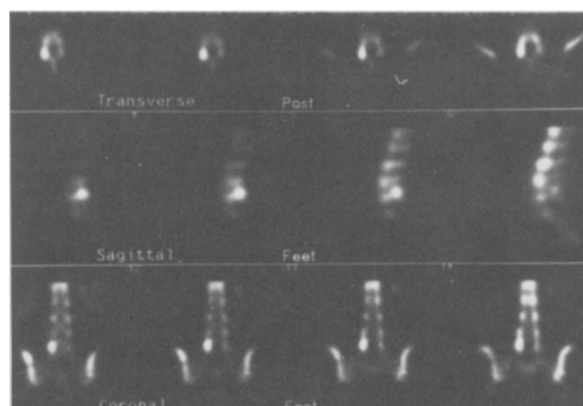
Osseous tomoscintigraphy (=SPET, using Tc-99m DPD) of the lumbar spine in a patient with low back pain. Selected are transverse (top), sagittal (center) and coronal slices (bottom). Maximum uptake is seen in a lesion that includes the right intervertebral (=facet-) joint, but extends to the adjoining articular and lateral process: reactive spondylarthrosis, or 'activated facet syndrome'.
